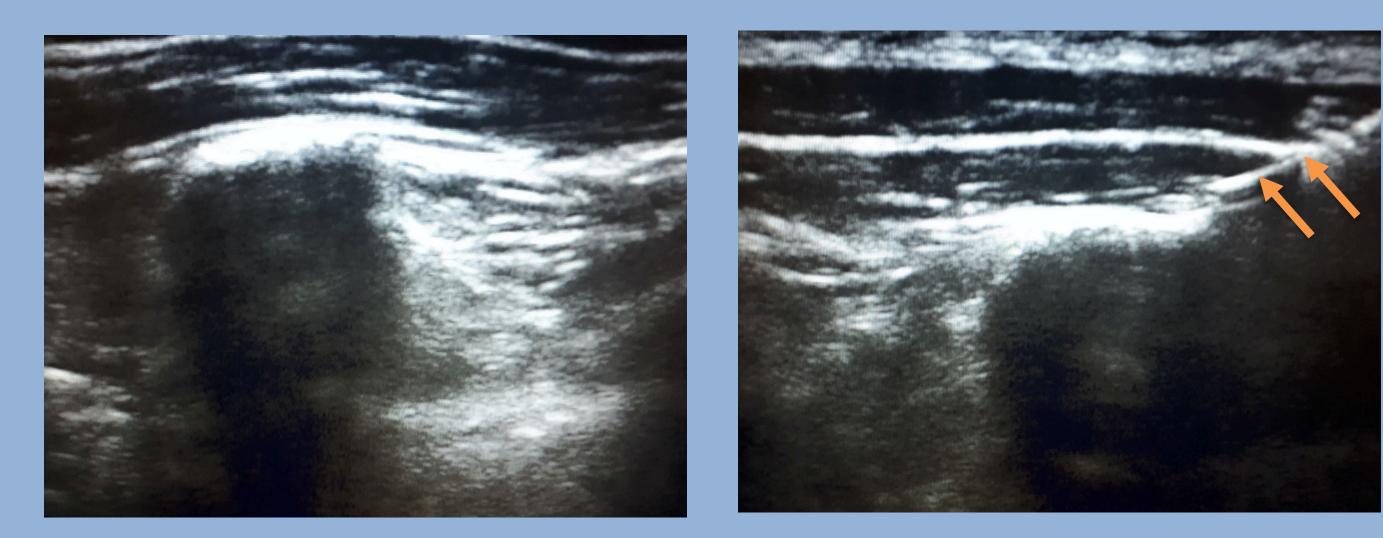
Ultrasound imaging at T7 level
